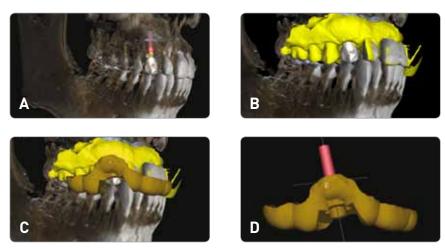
Planning and guide design using Blue sky plan III software. A. Decide the implant position corresponding ideal prosthesis. B Merge the CT and intraoral scan data. C. Design the guide outline. D. Automatically fabricated surgical guide.
